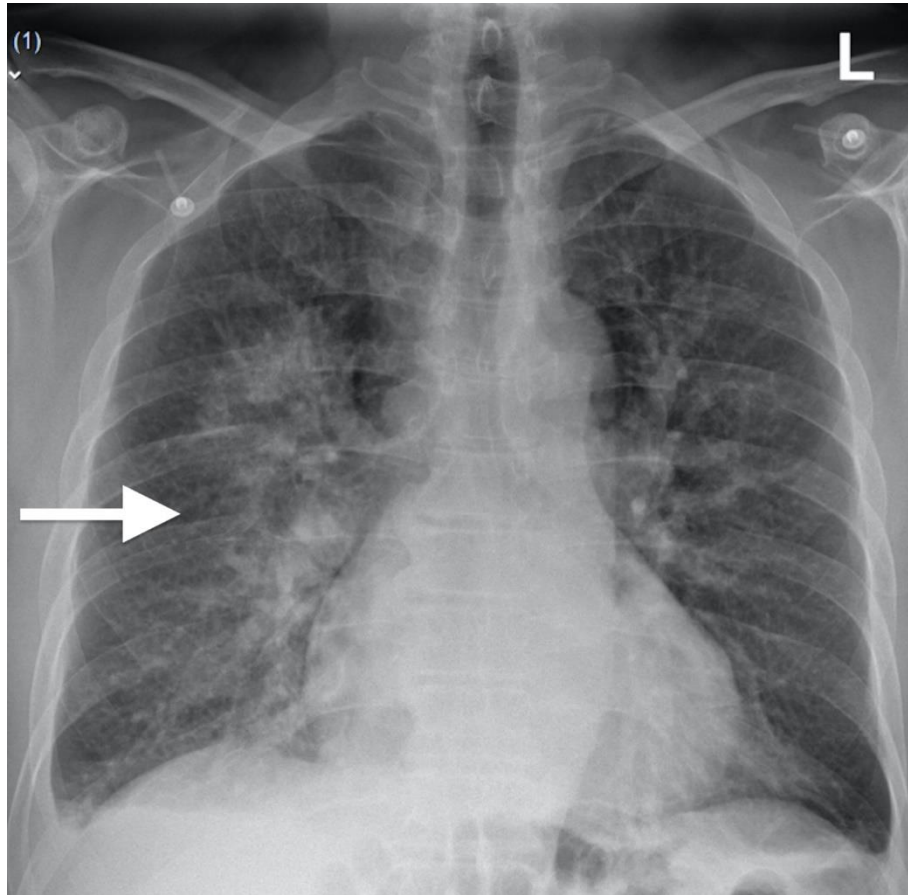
Antero-posterior chest xray demonstrating predominantly right-sided pulmonary oedema (see arrow).
